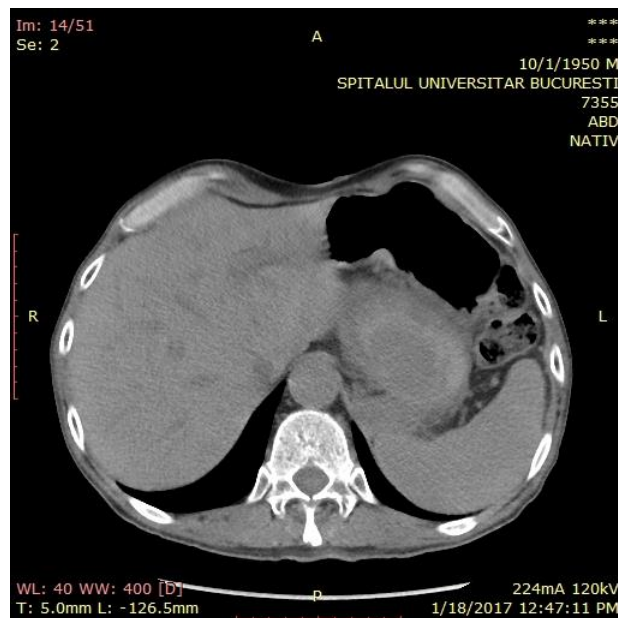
Native CT scan axial section – upper abdomen. 12x6.5cm spontaneously inhomogenous pseudocyst to the body and tail of the pancreas.
